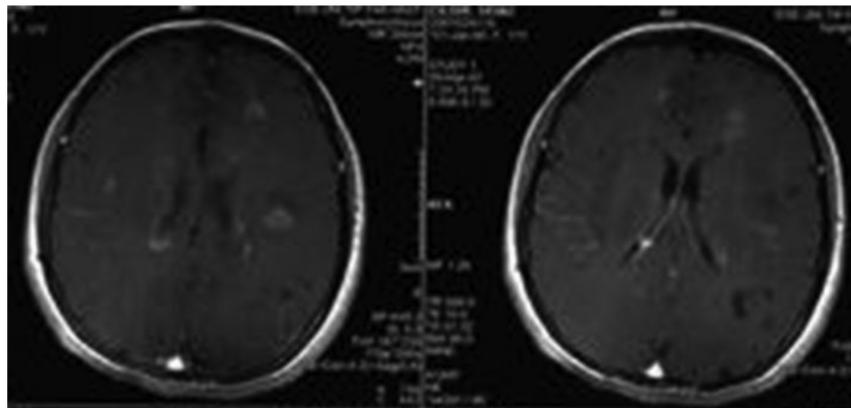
Gadolinium enhanced demyelinating plaques and black holes on T1-weighted sequences.
